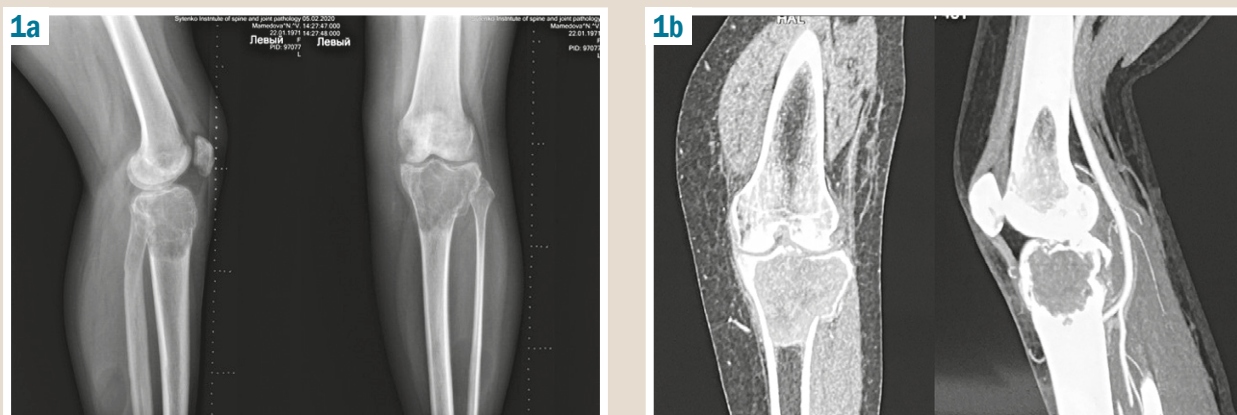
X-ray images (a) and CT (b) of the PT, patient M., 49 years old.
